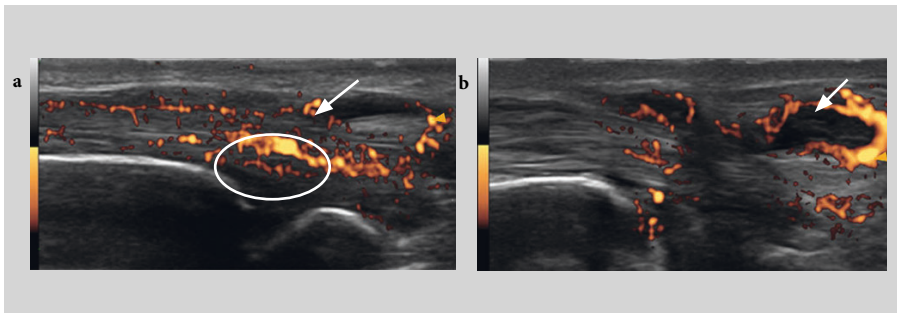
Examples of ultrasound longitudinal scan of extensor ulnaris carpi. Severe tenosynovitis in both grayscale and power Doppler signal within the tendon sheet (arrows) and inside the tendon (circled).
